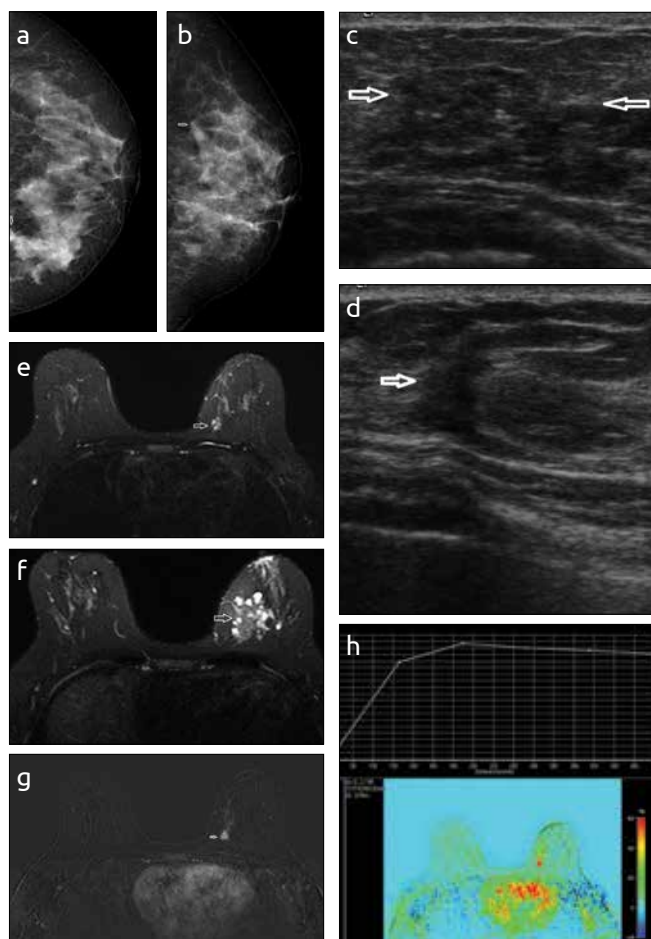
a-h (mass 4). A 45-years-old woman with palpable mass in the lower-inner quadrant of the left breast. Craniocaudal (a) and mediolateral (b) oblique mammography images showed not only a 30x15 mm high-density irregular mass with amorphous calcification in the lower-inner quadrant, but also 8x7mm high-density irregular mass with indistinct margins (arrow), which proved to be tubular carcinoma in the upper-inner quadrant of heterogeneous dense parenchyma. Sonography (c) of that palpable area showed a predominantly solid mass with internal cystic spaces and calcification (arrows). Tubular carcinoma was an irregular hypoechoic mass (d) with angulated border (arrow). Axial T2-weighted images with fat suppression shows 8 mm hyperintense lobulated tubular carcinoma with dark internal septation (arrow) (e) and hypointense mass with milimetric cysts that proved to be stromal fibrosis (f). TC shows homogenous contrast enhancement with Type-3 dynamic analysis on T1-weighted gadolinium-enhanced subtraction image (2.second) (g), (h)
